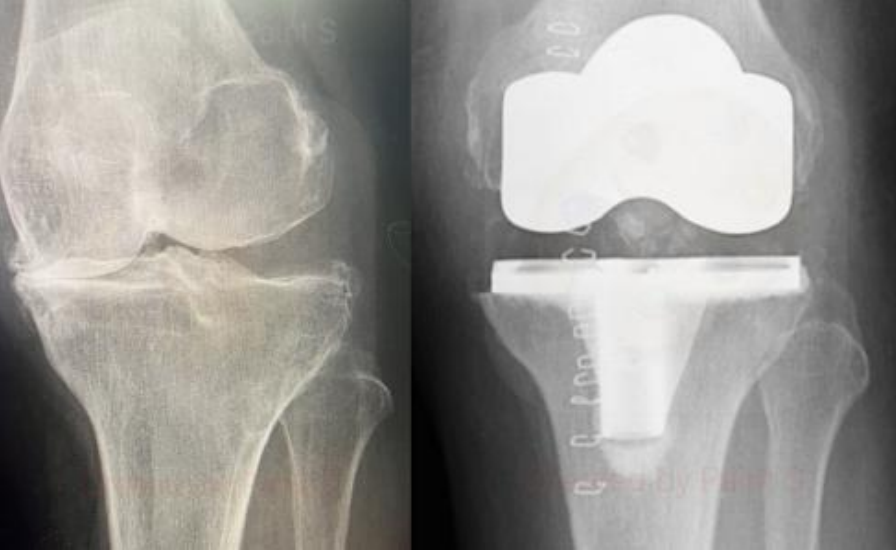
X-rays of the knee. On the left is a typical appearance of a knee with osteoarthritis, which shows bone on bone contact, indicating that the cartilage has worn out. On the right is a post-operative X-ray showing an implant has replaced the diseased part of the knee.
